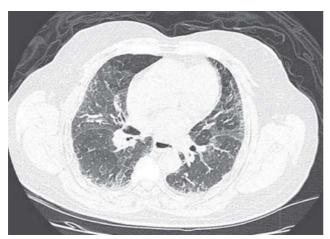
High-resolution computed tomography of thorax showing subpleural, interlobular and intralobular thickening with patchy ground-glass appearance.
